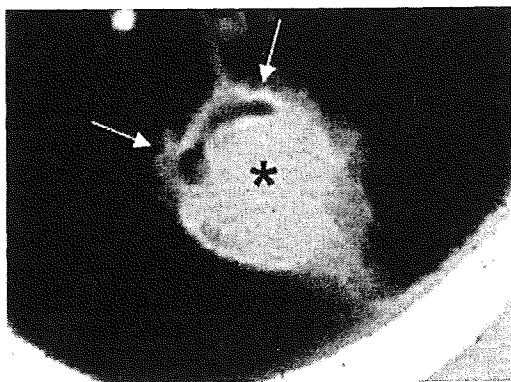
CT air crescent sign in IPA. The CT image demonstrates an air crescent sign in a patient with angio-invasive pulmonary aspergillosis and underlying hematological malignancy. A crescent of air (arrows) surmounts a soft tissue mound of a macronodule (*).
